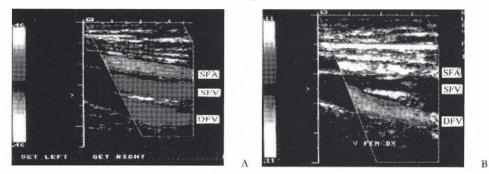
Colour coded Doppler image with A: normal blood vessels. B: Valsalva-test demonstrating an incompetent deep femoral vein (DFV), (red colour).
